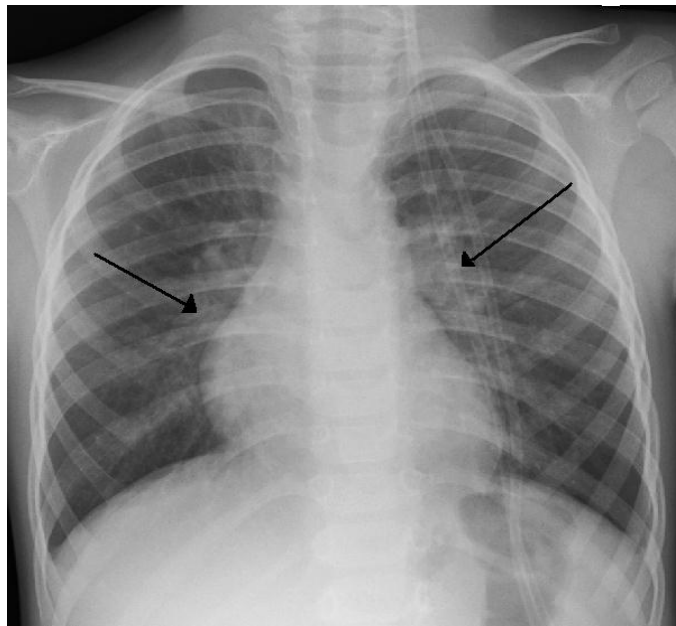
This X-ray shows:
